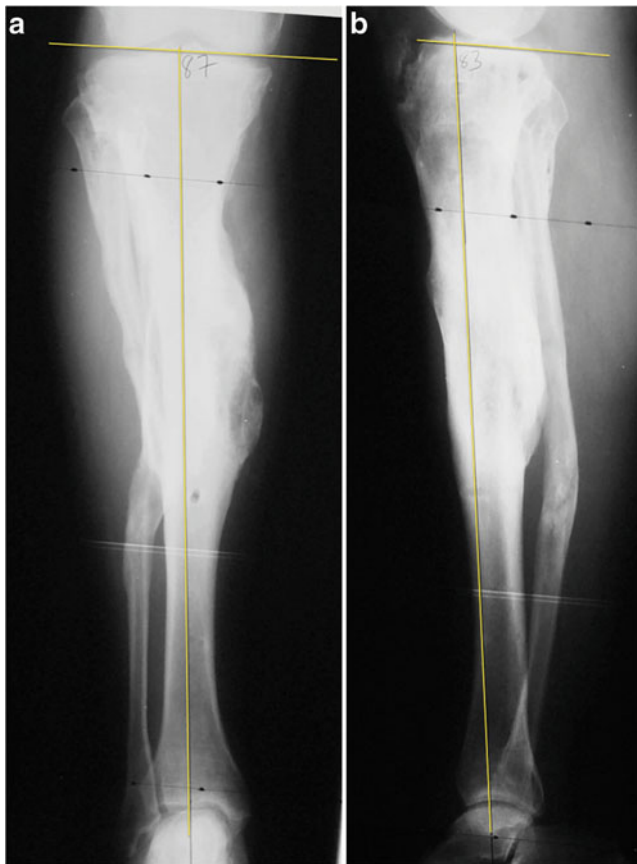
Final (a) AP and (b) lateral radiograph at 2.5-year follow-up. Medial proximal tibial angle measured 87° and proximal posterior tibial angle measured 83°
